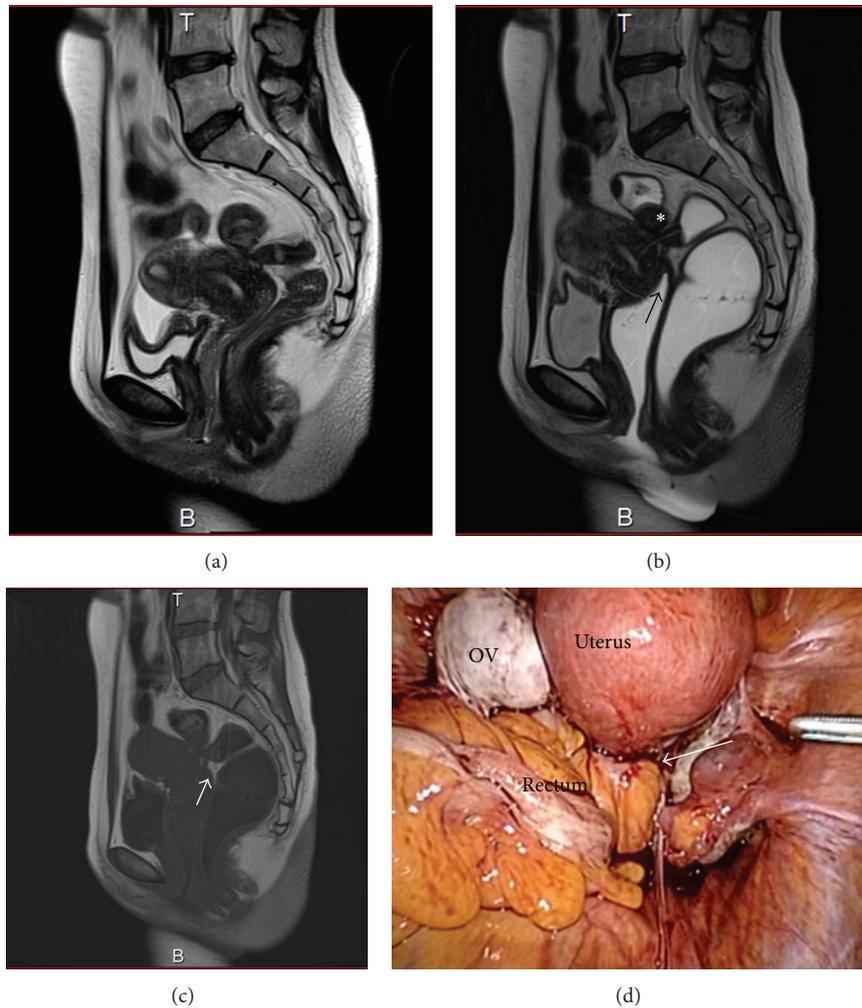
(a) MR image obtained before jelly administration in a patient with ovarian cyst and CCDSO. (b) MR image obtained after jelly administration in the same patient. The posterior vaginal vault is tethered (black arrow). The rectal surface is tethered (asterisk). (c) T1WI from the same patient showing a high-intensity lesion (white arrow). (d) Pelvic laparoscopy findings in the same patient. The ovarian cyst and obliterated Pouch of Douglas are seen (white arrow).
